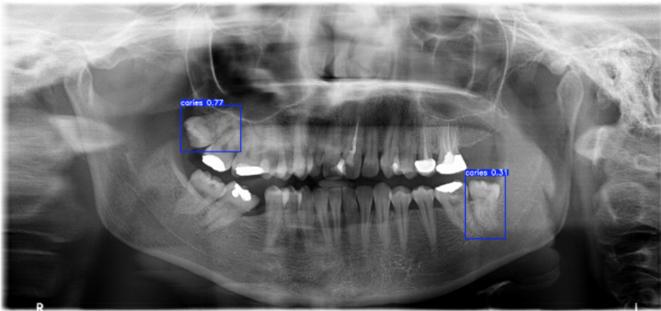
Example of object detection on a panoramic dental X-ray. The YOLOv5 model detects caries with associated confidence scores.
